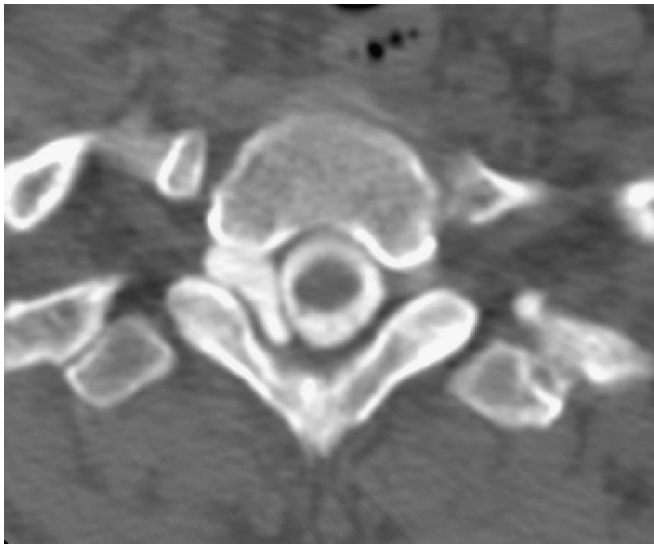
Post-traumatic pseudo-meningocele. Axial image from a CT myelogram demonstrates a posttraumatic pseudo-meningocele (arrow).
